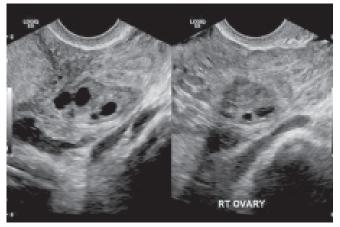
Transvaginal ultrasound scan of a complex ovarian mass in a patient with positive pregnancy test and no evidence of intrauterine pregnancy
